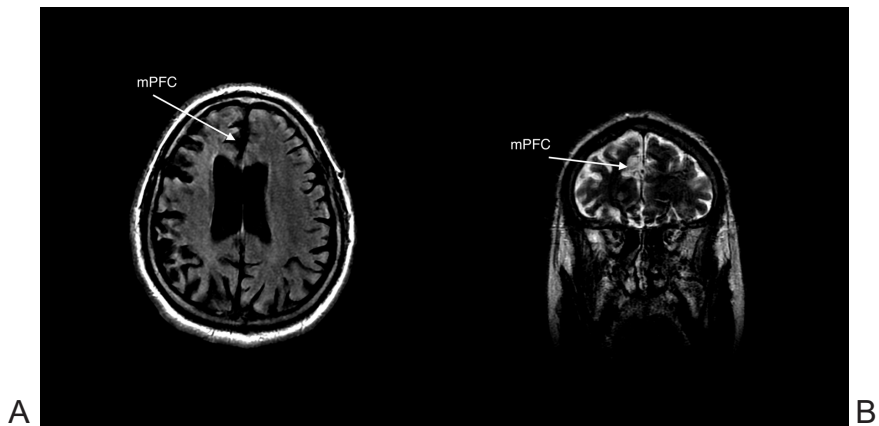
Brain MRI, a. FLAIR T2 sequence: axial plane: predominant atrophy of the right medial prefrontal cortex (mPFC arrow), b. frFSET2 sequence, coronal plane: predominant atrophy of the right medial prefrontal cortex (mPFC arrow)
